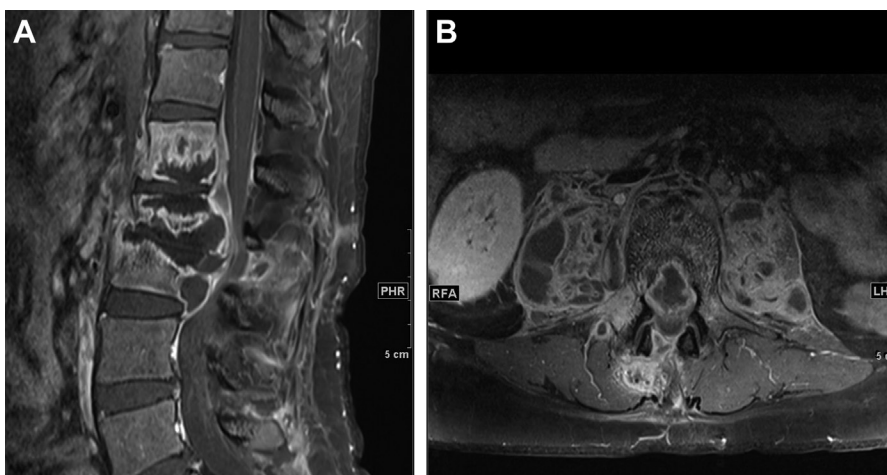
Tuberculous spondylitis with abscess formation. Sagittal (A) and axial T1-weighted postcontrast MR imaging (B) show well-defined thin, rim-enhancing paraspinous, intraosseous, and epidural abscess with nonenhancing central cavity. There is also bilateral psoas abscess formation.
